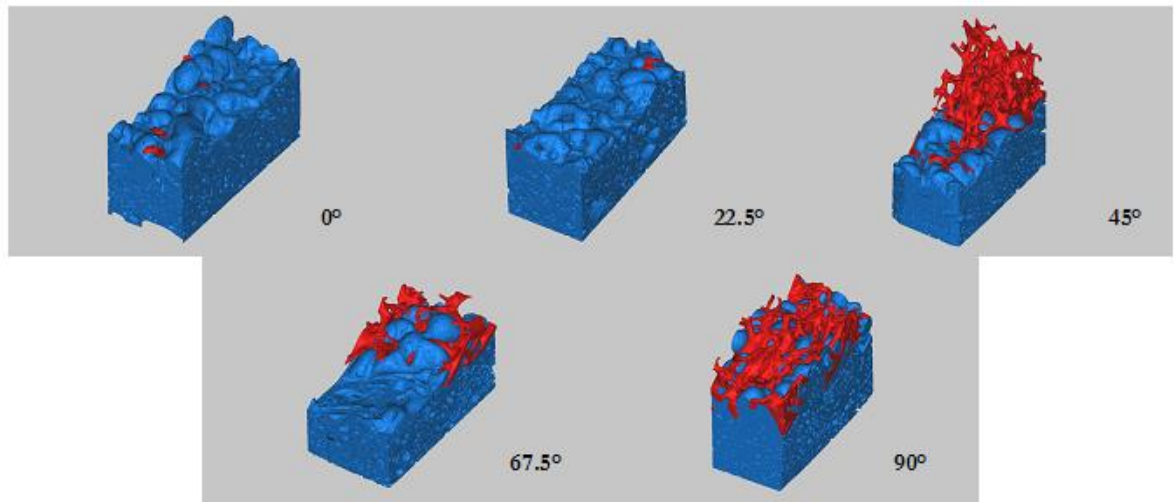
5: Morphologies of some of the failed bone-cement interface samples tested under tensile (0°), mixed mode (22.5° , 45° , 67.5°) and shear (90°), examined using μ CT scanning. Note bone and cement are marked accordingly (bone-red; cement-blue) (Wang et al., 2010).
